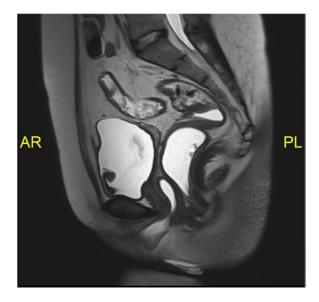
The sagittal section of the MRI showed that the uterus was not well visualized.
